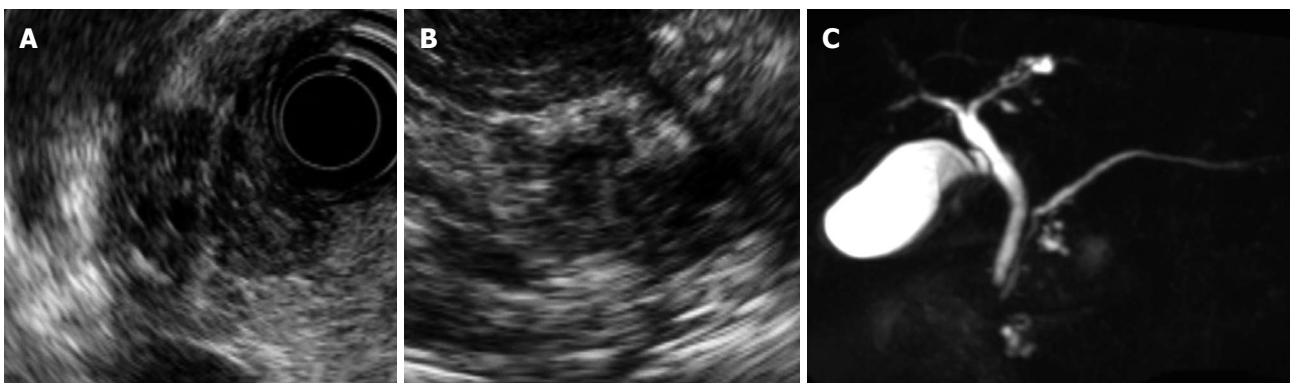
Imaging studies at follow-up examination. A, B: Endoscopic ultrasonography revealed solid lesions in or around both cystic lesions in the pancreas head. Hyperechoic foci and strands were observed in these lesions; C: Magnetic resonance cholangiopancreatography showed a reduction in the diameter of both cystic lesions.
